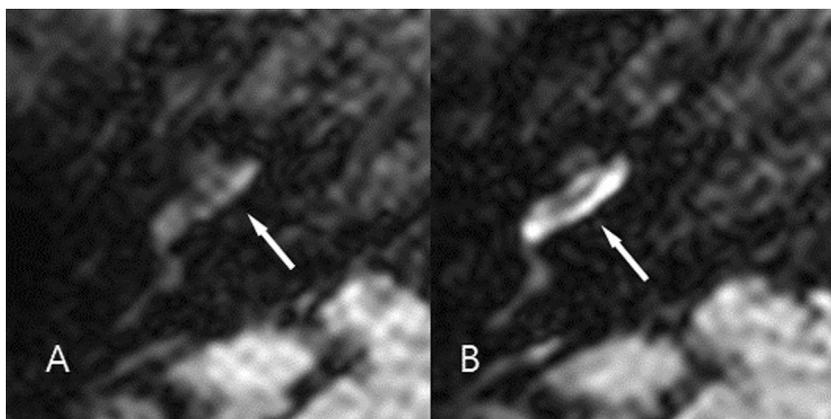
Temporal MRI of a 20-year-old woman with MD in the right ear. The pre-treatment pure tone audiometry of the right ear revealed a 62 dB hearing loss. (A) Axial 3D-FLAIR image shows high signal intensity (mean \pm SD, 33.3 ± 8.2) in the right cochlea (arrow). (B) Axial CE-FLAIR image shows strong contrast enhancement (mean \pm SD, 87.7 ± 28.5) at the basal and mid turns of the cochlea (arrow). The post-treatment pure tone audiometry of the right ear revealed that hearing loss had improved to 21 dB.
